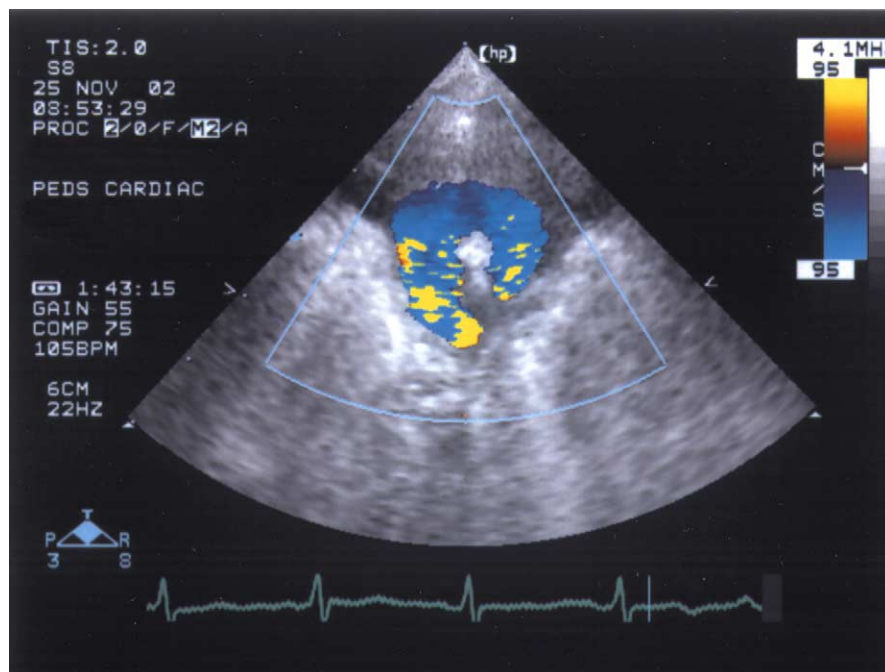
Color doppler image of great vessels via echocardiogram in our patient with double aortic arch. Vascular ring is clearly demonstrated surrounding the trachea.
